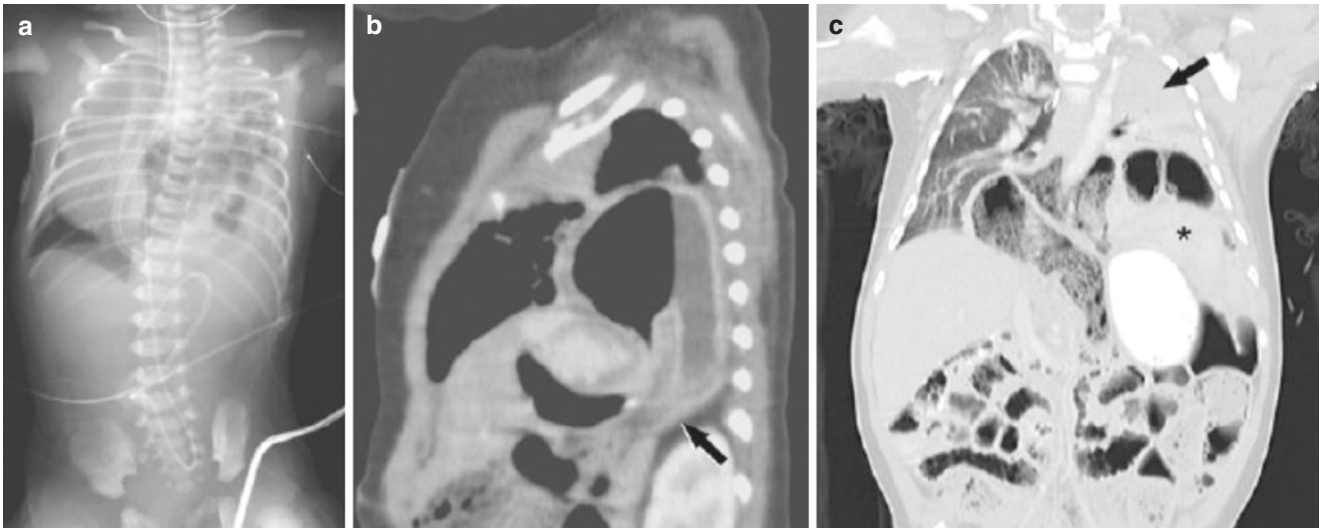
Bochdalek hernia. (a) Frontal view of the chest and abdomen showing numerous loops of air-filled bowel in the left hemithorax. There is significant mediastinal shift to the right. (b) Sagittal CT of the chest and abdomen reveals the posterior diaphragmatic defect (*arrow*)
